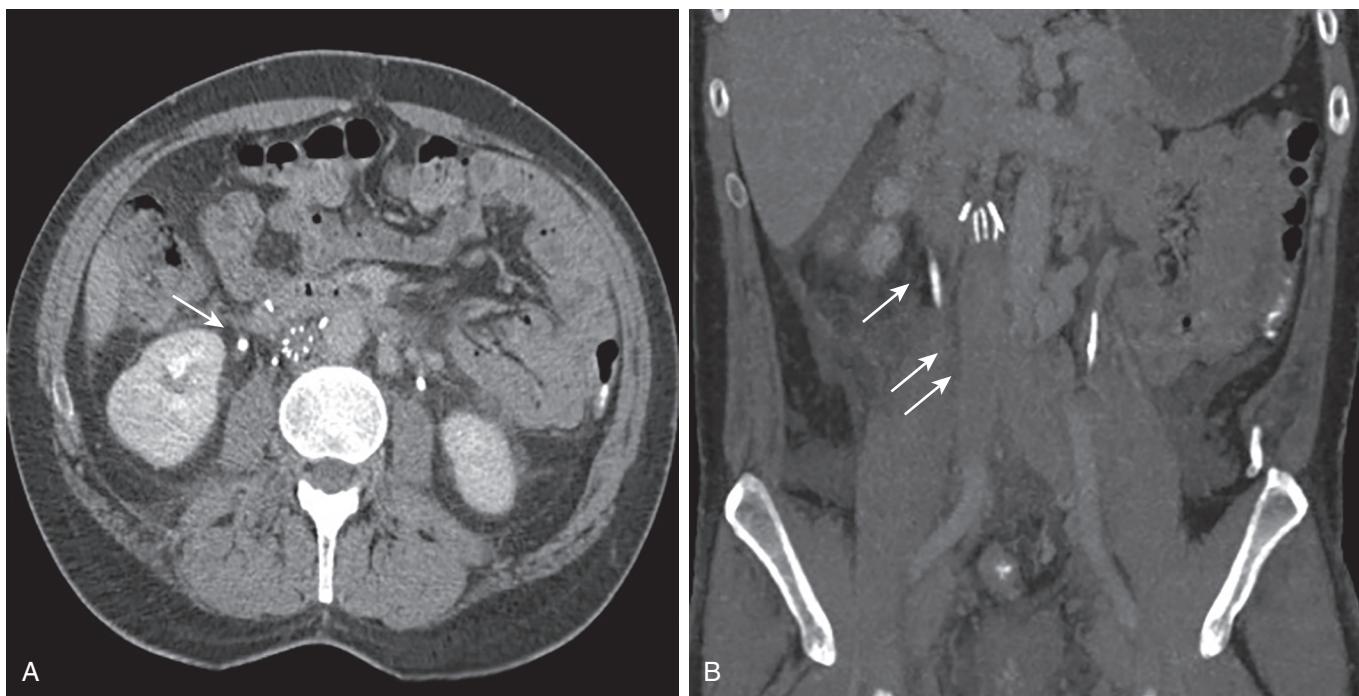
CT scan for abdomen and pelvis in sagittal (A) and reconstructed (B) views demonstrating strut fracture and migration (single arrow), thrombosis of inferior vena cava inferior to the filter (double arrows) and perforation of filter struts in the bowel retroperitoneum and near the aorta.
